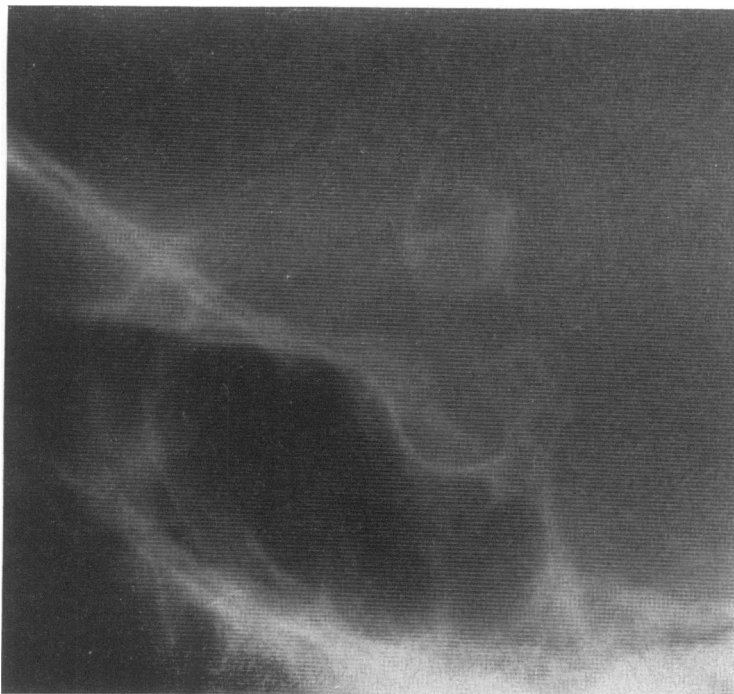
Detail of plain lateral skull radiograph of Case 2 showing calcification both within the substance of the aneurysm and in the surrounding wall.
